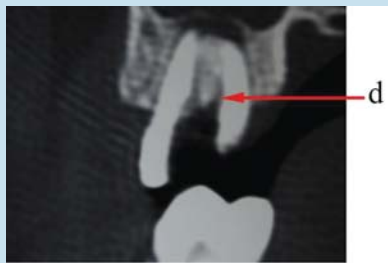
Spiral CT Image showing (d) an incomplete lateral extension
